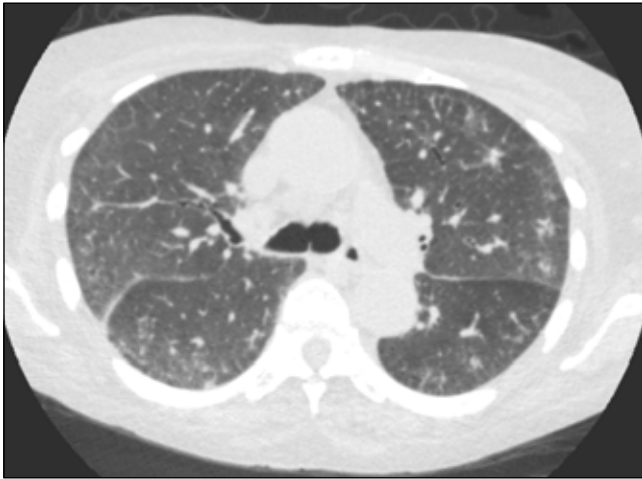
Follow-up transaxial CT chest image demonstrating marked improvement in interstitial changes.
